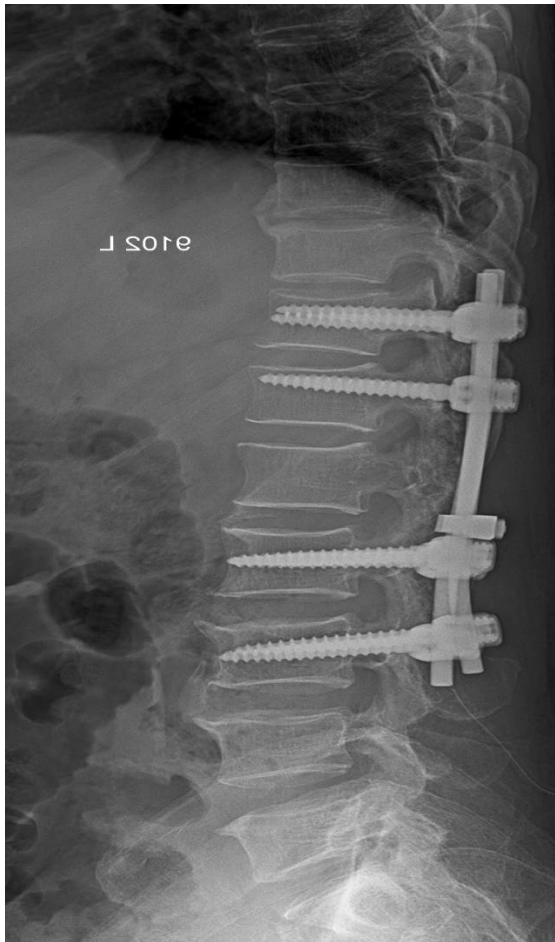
Post-op radiograph showing T11- L3 instrumented postero-lateral fusion.
